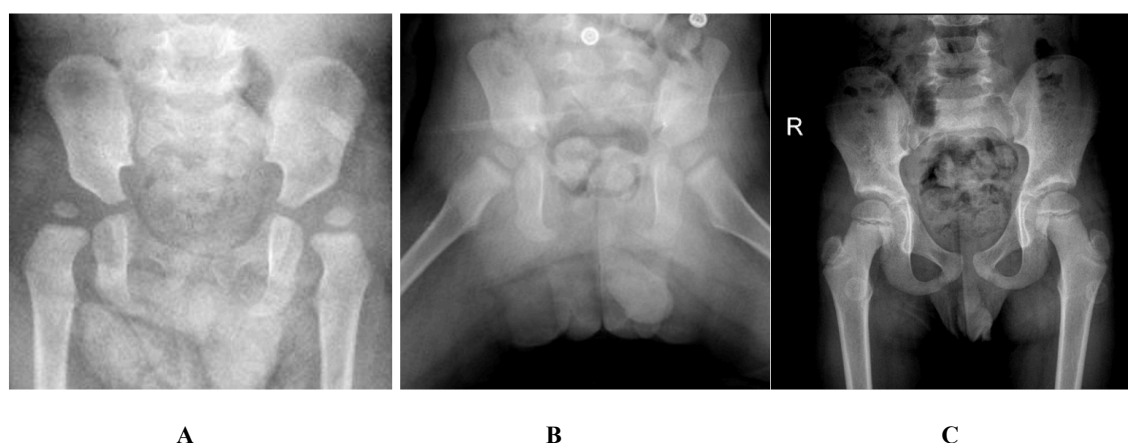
(A) Pre-reduction pelvic AP radiograph (20th month), (B) Post-reduction pelvic AP radiograph (24th month), (C) Post-reduction pelvic AP radiograph (96th month). A single AP radiograph is the most appropriate examination in children with DDH where femoral head ossification has occurred. And the frog leg lateral view is a special radiograph of the pelvis to evaluate the hip to reduce exposure and maintain high diagnostic accuracy.
